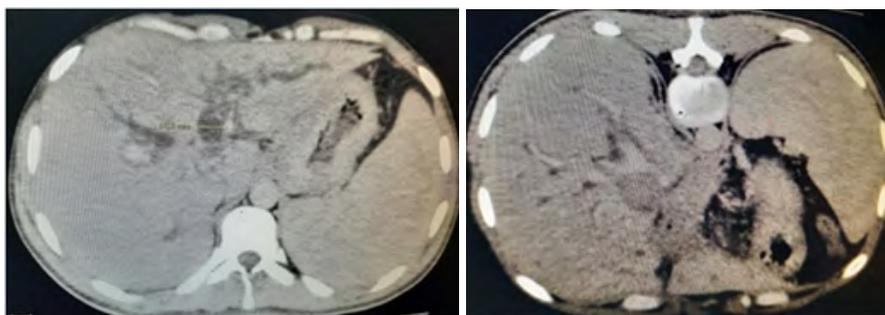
Abdominal CT :1: Axial view: Hilar lymph node magma on an axial view (a), dilatation of the intrahepatic bile ducts (b)
